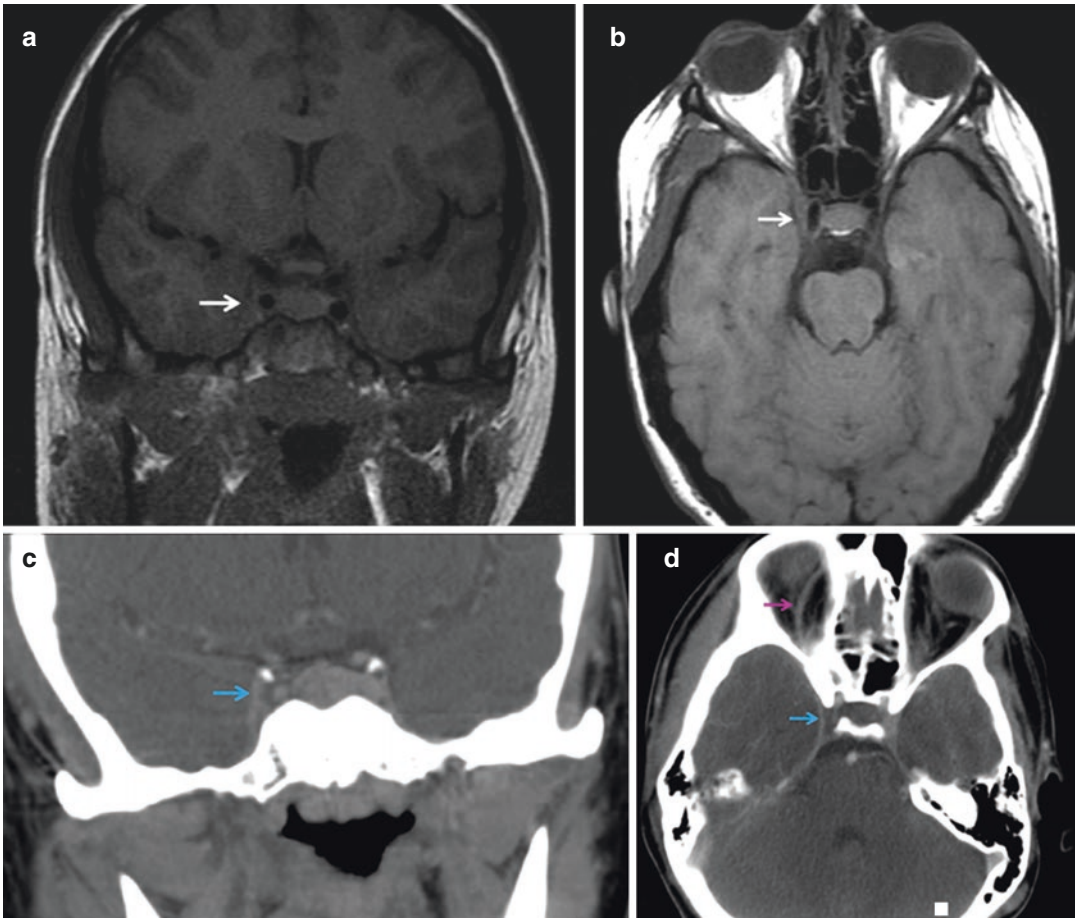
Cavernous sinus thrombosis. (a) T1-weighted MRI at level of the cavernous sinus, thickening of the right cavernous sinus (arrow). (b) T1-weighted MRI at the level of orbits, thickening of the right cavernous sinus (arrow). (c) Soft tissue window coronal CT with areas of low attenuation within cavernous sinus representing
